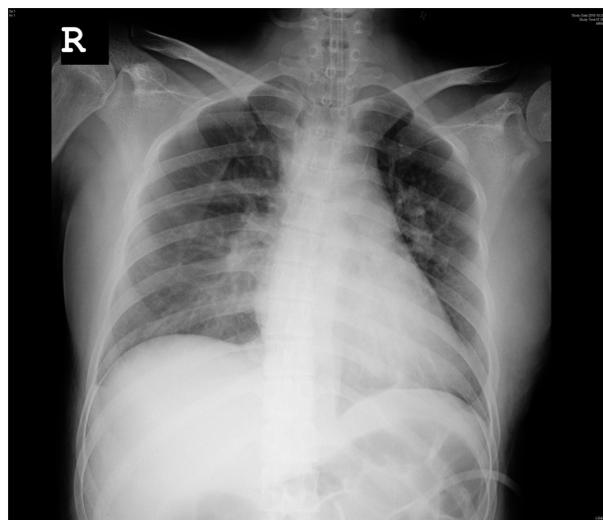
Chest AP X-ray showed pulmonary edema.
